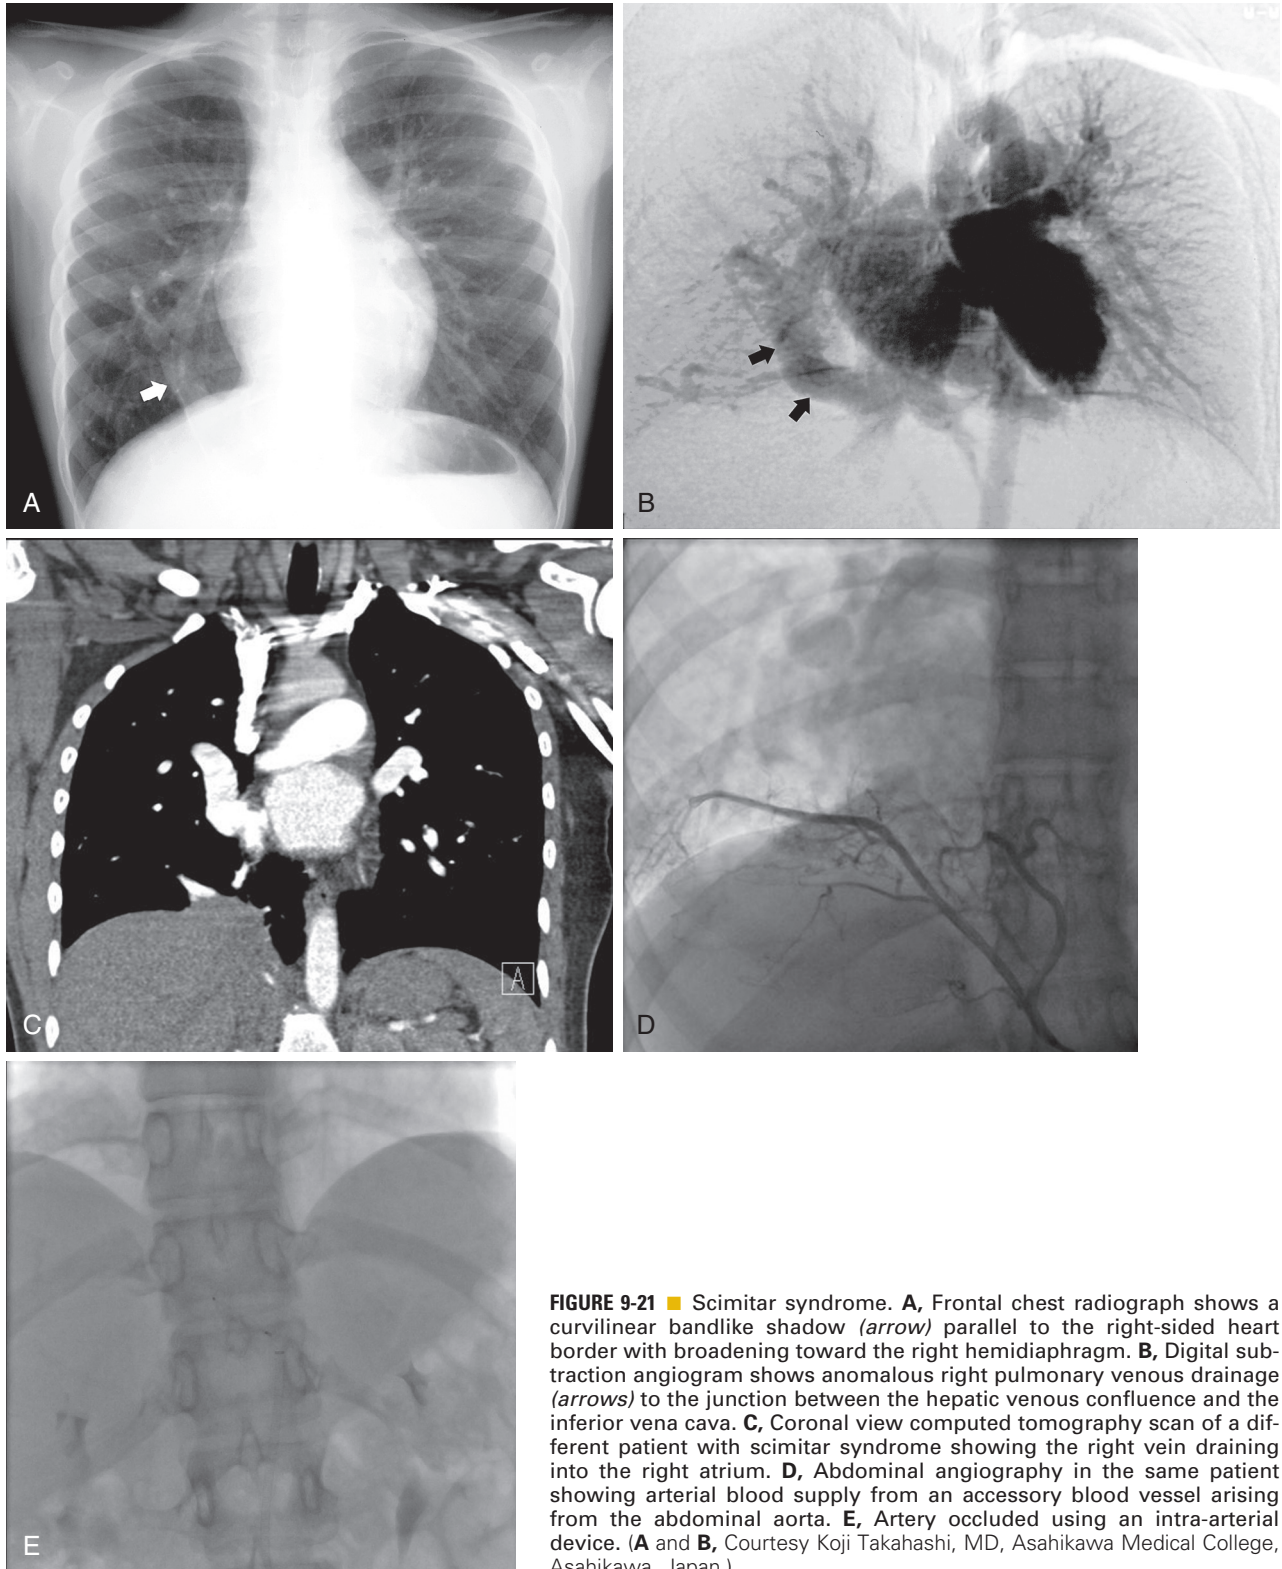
■ Scimitar syndrome. A, Frontal chest radiograph shows a curvilinear bandlike shadow (*arrow*) parallel to the right-sided heart border with broadening toward the right hemidiaphragm. B, Digital subtraction angiogram shows anomalous right pulmonary venous drainage (*arrows*) to the junction between the hepatic venous confluence and the inferior vena cava. C, Coronal view computed tomography scan of a different patient with scimitar syndrome showing the right vein draining into the right atrium. D, Abdominal angiography in the same patient showing arterial blood supply from an accessory blood vessel arising from the abdominal aorta. E, Artery occluded using an intra-arterial device. (A and B, Courtesy Koji Takahashi, MD, Asahikawa Medical College, Asahikawa, Japan.)
